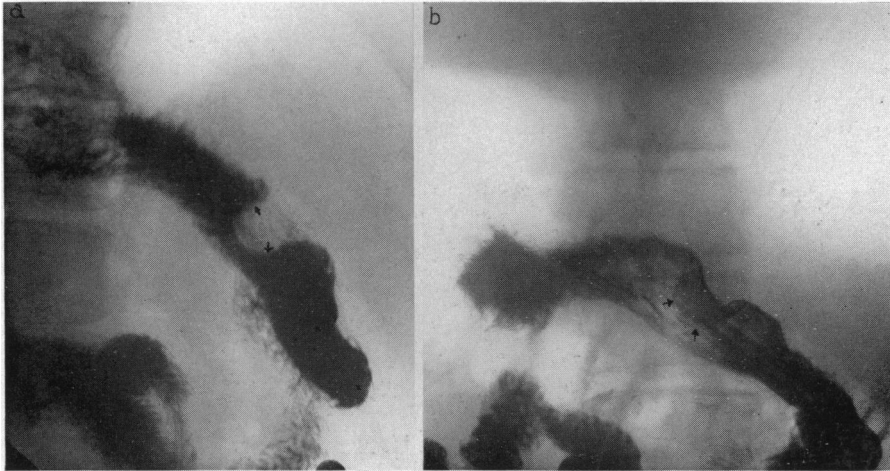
Case 3: (a) Note the typical roentgenographic defect; (b) note the completeness of the outline of the tumor in the roentgenogram. This is no guarantee of the absence of malignancy.
